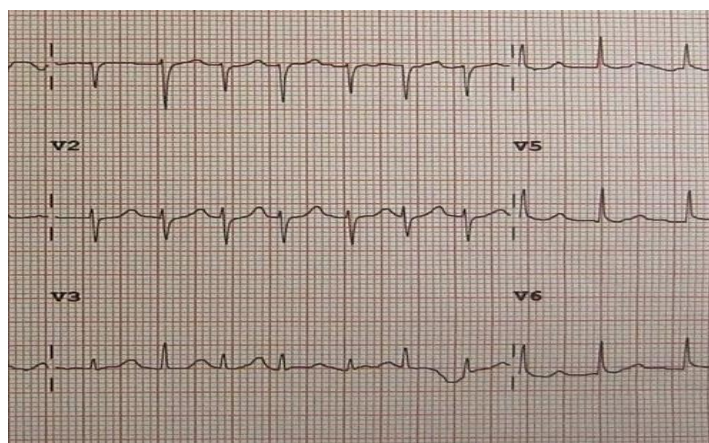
Example of QRS alternans in amplitude in V1-3 standard transthoracic echo.
